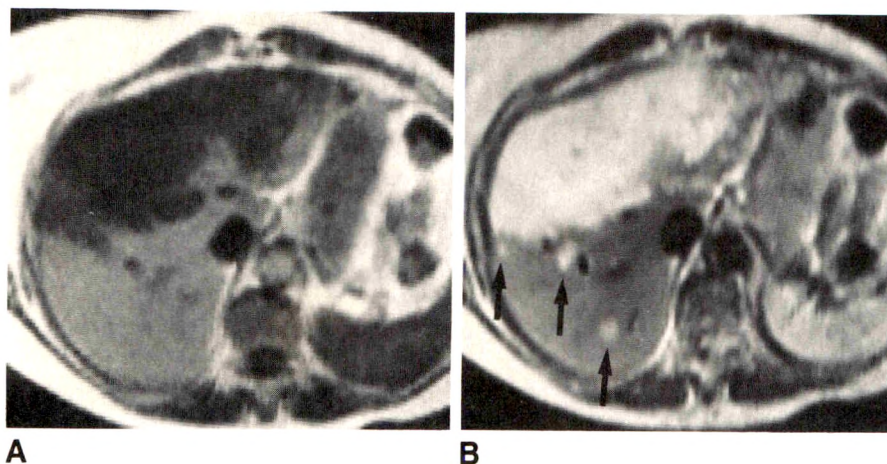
Multifocal hepatocellular carcinoma. A, T1-weighted spin-echo image, 260/14, shows large hypointense tumor mass involving both right and left liver.
